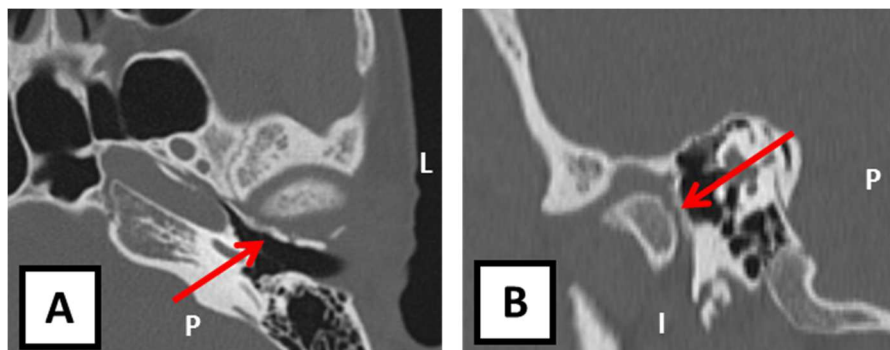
Postoperative CT scan (0.6 mm slice thickness) of the left external auditory canal demonstrating the closure of the foramen tympanicum by the osseointegrated iliac crest bone graft (red arrow). Axial view (A). Sagittal view (B).
